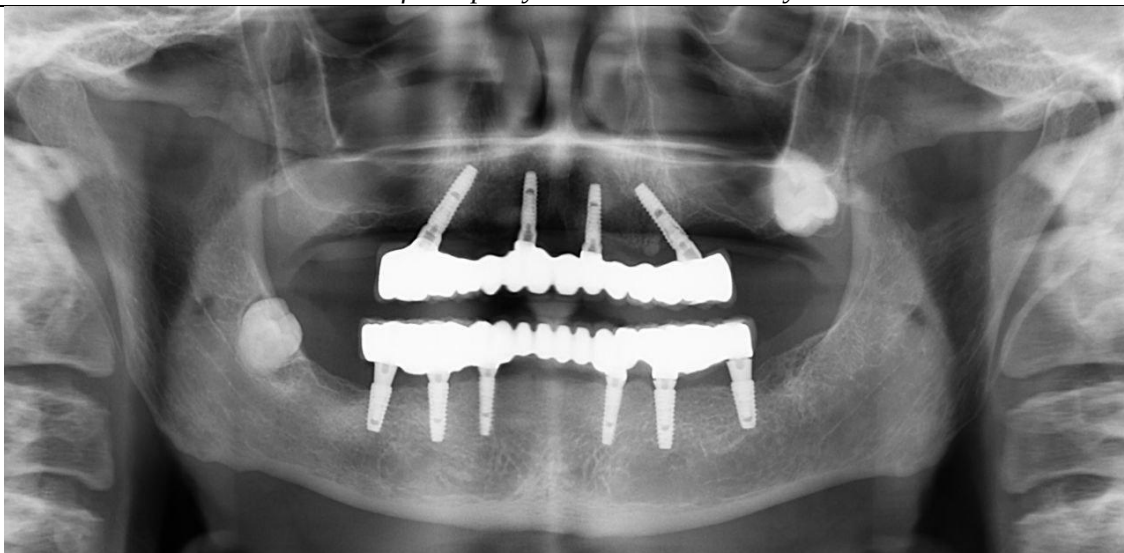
Post-operative orthopantomogram (OPG).
